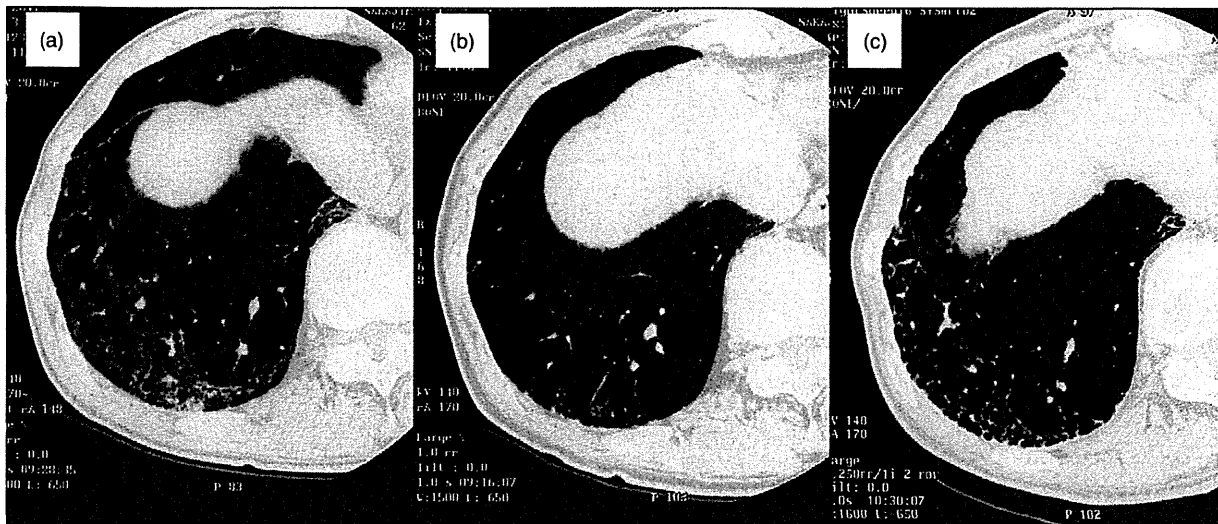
Follow-up high resolution computed tomography. (a) At admission, extensive ground-glass opacities (GGO) with thin-walled cysts were seen in the peripheral area of the right lower lobe. (b) Two years later, there was a marked decrease in GGO, but the presence of thin-walled cysts was suspected. (c) Eight years later, honeycombing shadows had newly appeared in the peripheral region.
